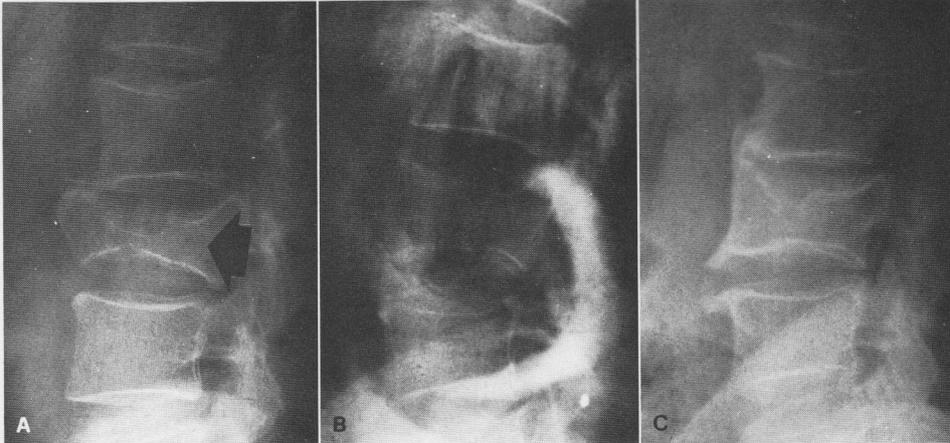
(A) Male aged 47 years with a burst fracture of L<sub>3</sub>. The initial radiograph shows a 3° kyphosis and more than 30% compression. (B) The post reduction radiograph in a hyperextension plaster shows good correction of the kyphosis (23° negative kyphosis = lordosis). The patient was recumbent for 40 days and wore the cast for 2 months. (C) The 8 years follow-up radiograph shows some loss of reduction, negative kyphosis of 12°, a residual compression of 15% and grade 4 spondylosis changes, with bridging osteophytes and anterior fusion. The patient had no symptoms.
